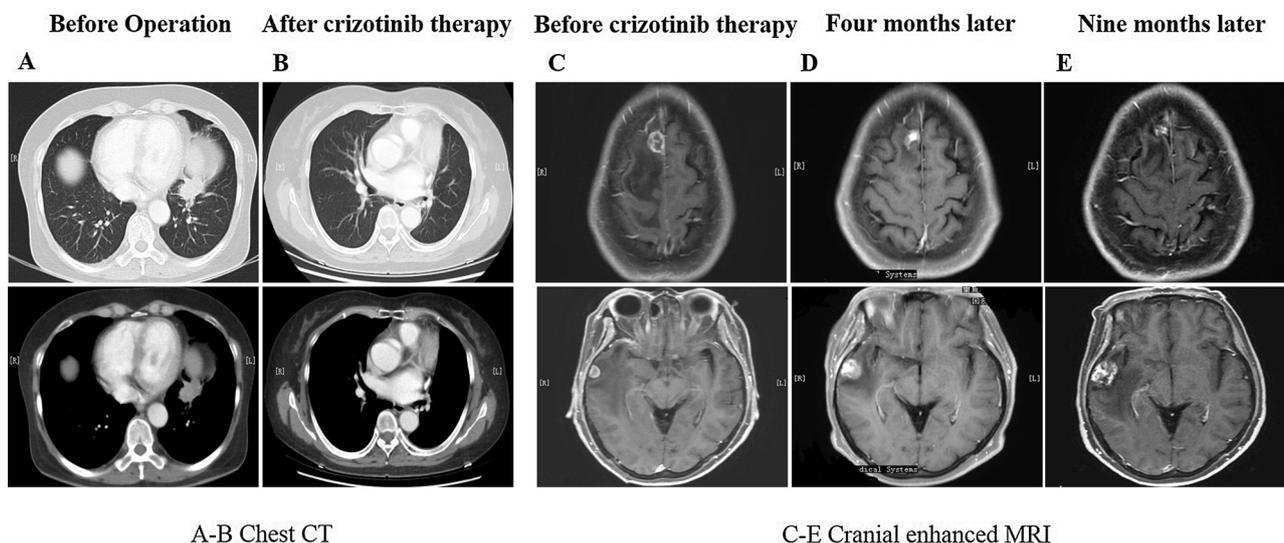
Chest computed tomography (CT) scans for case 24. CT showed the response to first-line chemotherapy before surgical resection (A), then the patient underwent tumor resection in the left lower lobe and received postoperative adjuvant chemoradiotherapy and showed no tumor growth. Nine months ago, crizotinib was administered, resulting in a stable response with no tumor growth up to the present time (B). Cranial enhanced magnetic resonance imaging (MRI) findings before and after crizotinib (4 months later and 9 months later). MRI before treatment revealed that (C) two metastatic loci were observed in the right frontal lobe and right temporal lobe, respectively. After treatment 4 months later (D) and 9 months later (E), the lesion of the frontal lobe remained stable while the lesion of the temporal lobe slightly increased.
